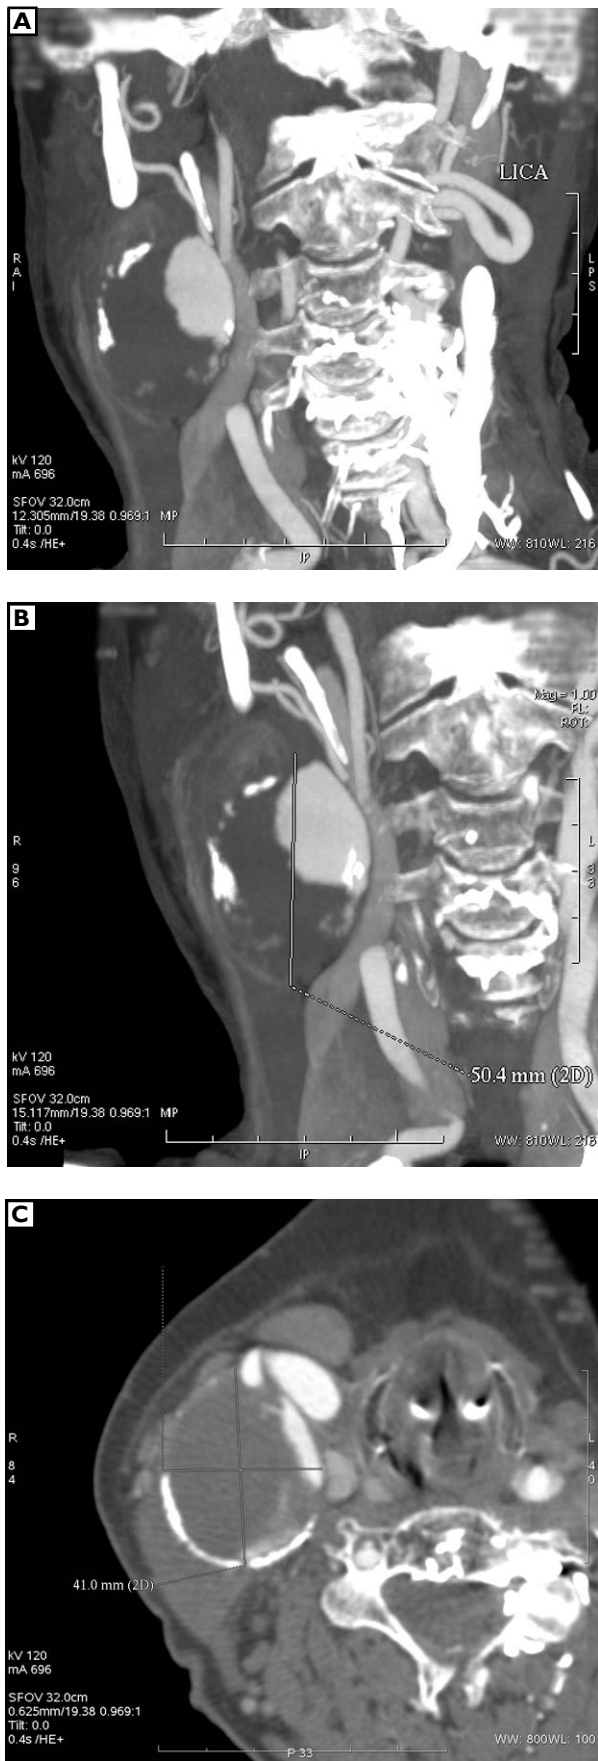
CT images (before the surgery)
